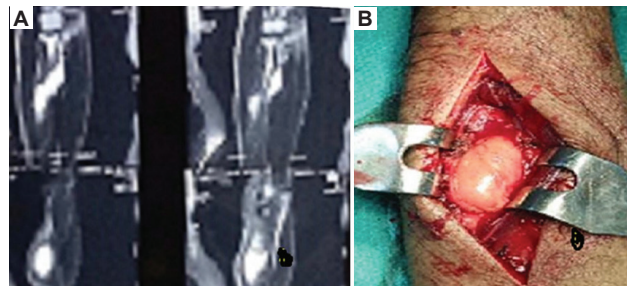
(A) Magnetic resonance imaging scan showed a $2.2 \times 2.4 \times 5.2$ cm lesion in the extensor compartment of the left forearm. It appeared hyperintense on the T1-weighted and T2-weighted images. (B) Intraoperative photograph showed that the tumor was lying beneath the extensor carpi ulnaris muscle over the supinator.
